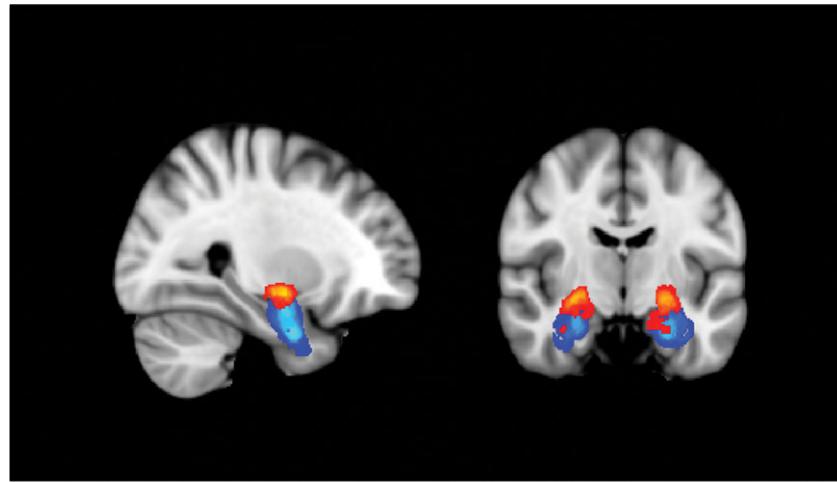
Centromedial amygdala (CMA) (right and left, Red) and basolateral amygdala (BLA) (right and left, blue) seed ROIs. The underlying brain template is from FSL MNI152 standard-space T1-weighted average structural template image
